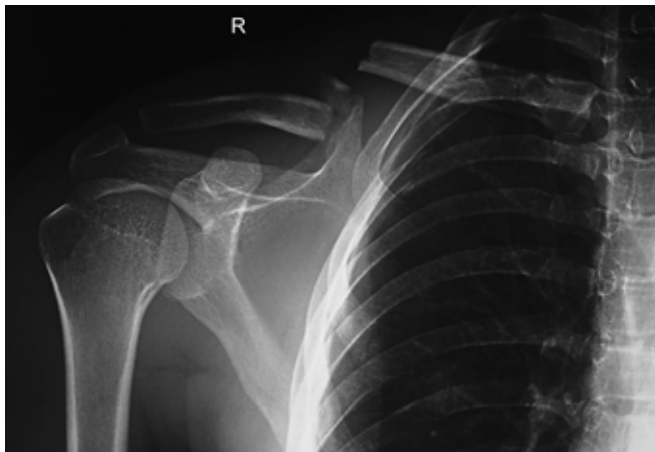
Anteroposterior X-ray of the shoulder showing fracture clavicle.
